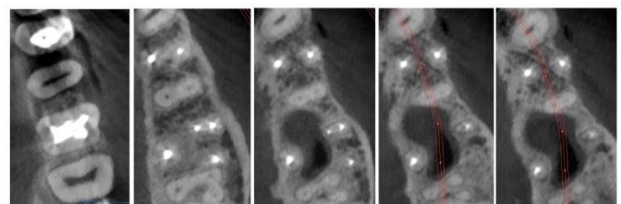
Consecutive post operative CB-CT imaging-axial view, confirming 2 independent canals.
